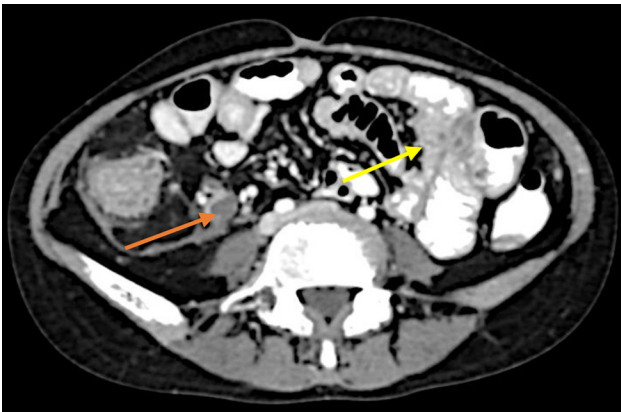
Diffuse circumferential wall thickening in the terminal ileum and ileocecal junction with luminal narrowing (yellow arrow) and necrotic lymph nodes (orange arrow) noted in axial section of contrast-enhanced computed tomography (CECT) abdomen.
